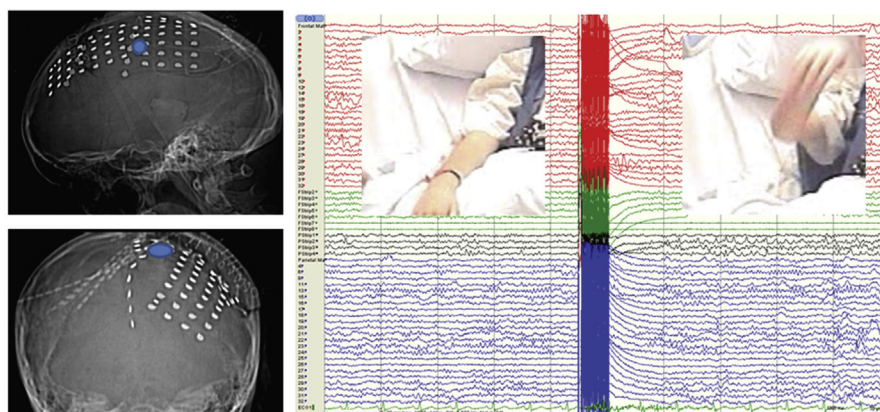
Functional stimulation of the primary motor hand area with subdural mats and strips over the frontal and the parietal lobe. (A) Lateral radiograph view. (B) Anterior posterior radiograph view. (C) Functional stimulation of contacts 7 and 9 of the subdural strip provoked elevation of the right hand. (Courtesy of International League Against Epilepsy, Flower Mound, TX)
